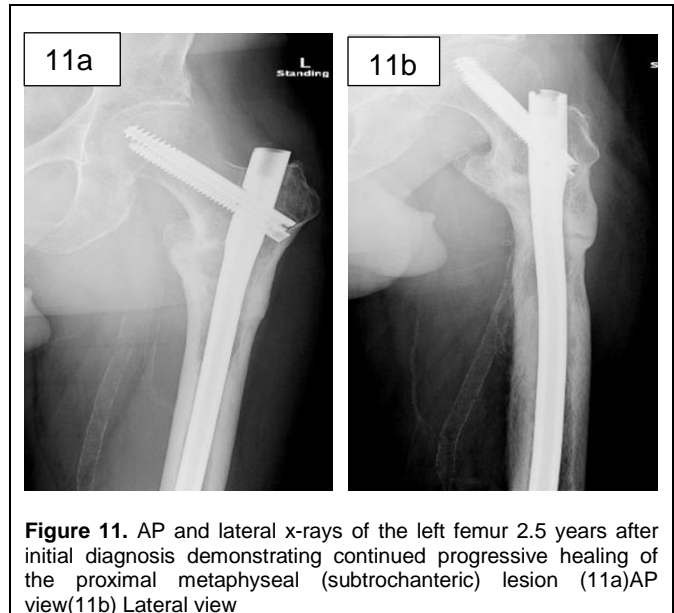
AP and lateral x-rays of the left femur 2.5 years after initial diagnosis demonstrating continued progressive healing of the proximal metaphyseal (subtrochanteric) lesion (11a)AP view(11b) Lateral view
